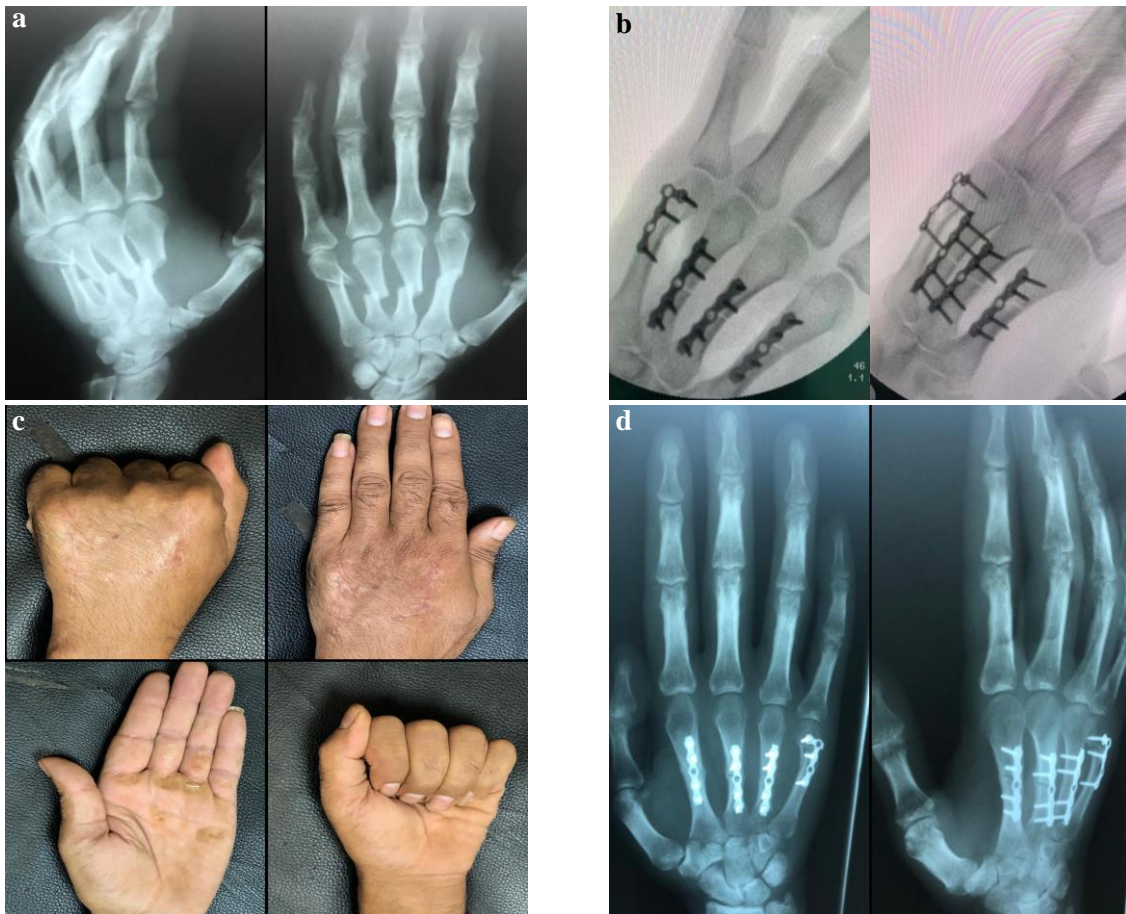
a. X-ray preoperative, b. X-ray postoperative, c. ROM after 1 year, d. X-ray after 1 year.
